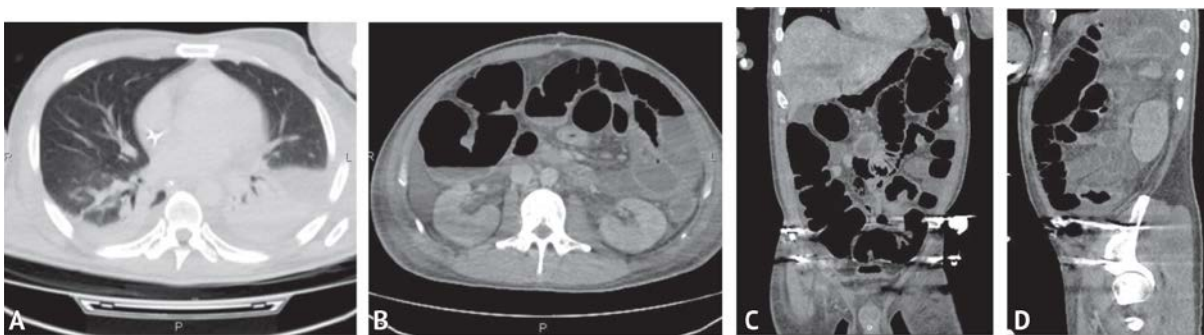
A – axial computed tomography of the chest. Bilateral pneumonia; B, C, D. Computed tomography of the abdomen in axial (B), frontal (C) and sagittal (D) planes. Hyperpneumatization of the small and large bowel loops, edema of the paracolic tissue. The intestinal wall is not thickened
